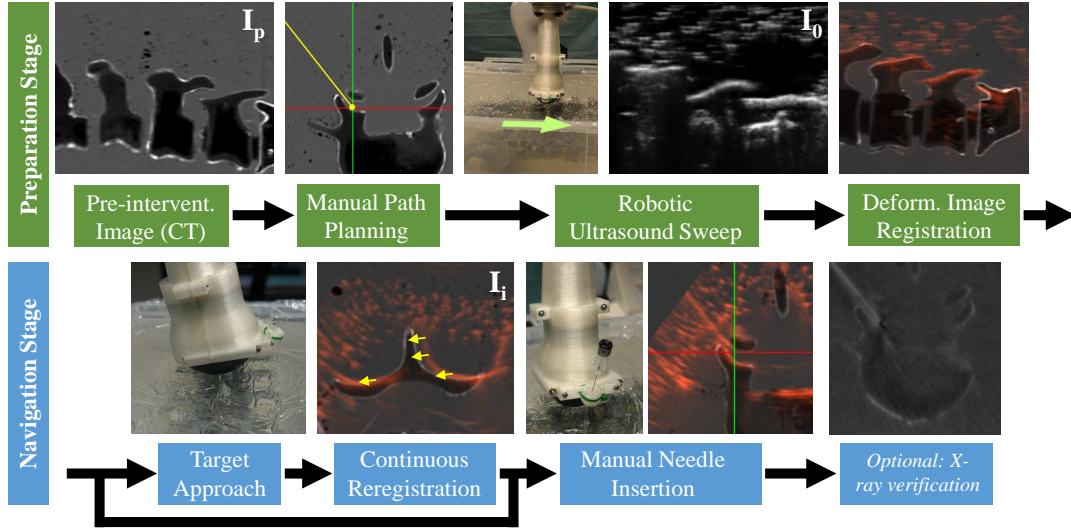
Workflow for facet joint needle insertion using the proposed ultrasound-based visual servoing guidance framework. In the preparation stage (green), a multi-modal set of images is acquired and registered to establish an interventional plan in the current patient coordinate system. Thereafter, the automatic navigation system takes over during the navigation stage (blue), maintaining registration over time and enabling precise manual needle insertion. *Reprint from [249] with permission of Springer.*
